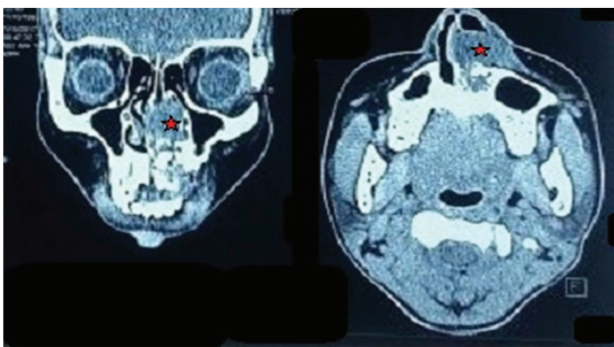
CT scan showing maxillary lesion (star).
